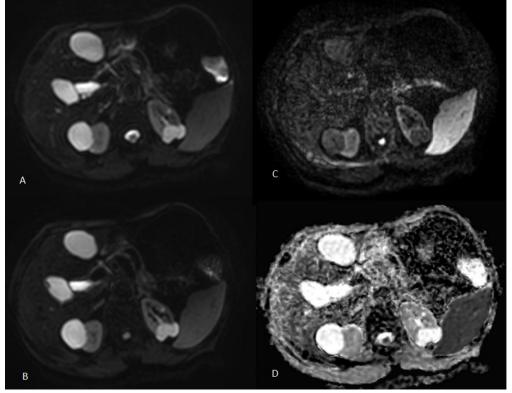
A well defined simple hepatic showing high signal at low b value DWI images (5A and 5B) and disappear at high b value (5C). No diffusion restriction is seen on ADC (5D).
